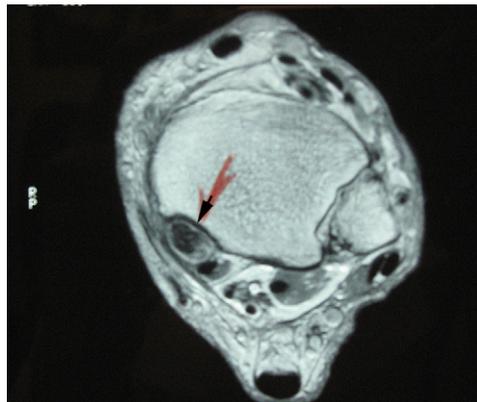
Axial (proton density weighted) MRI of an attenuated PTT. Arrow points to the posterior tibial tendon.
